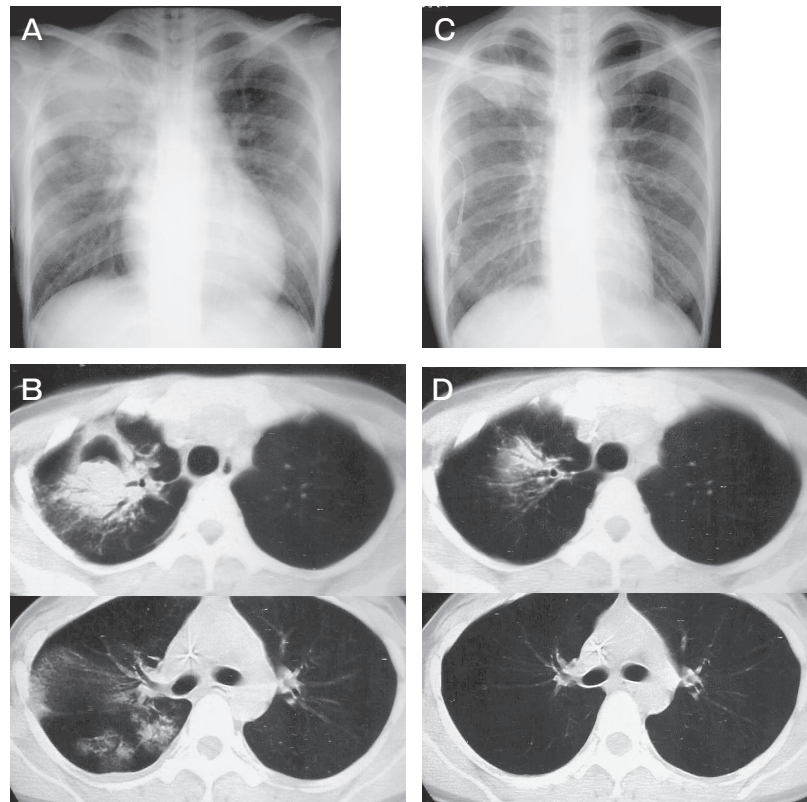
Chest X-ray and CT evaluation of the patient. A, Chest X-ray on September 20, showing pneumonia in the right upper lung; B, CT scan of chest demonstrates typical air-crescent signs and many consolidations in the right pulmonary lobe at one week after the start of VRCZ treatment; C, Chest X-ray on October 5, showing improvement of pneumonia; D, CT scan of chest demonstrates improvement at 3 weeks after the start of VRCZ treatment.
